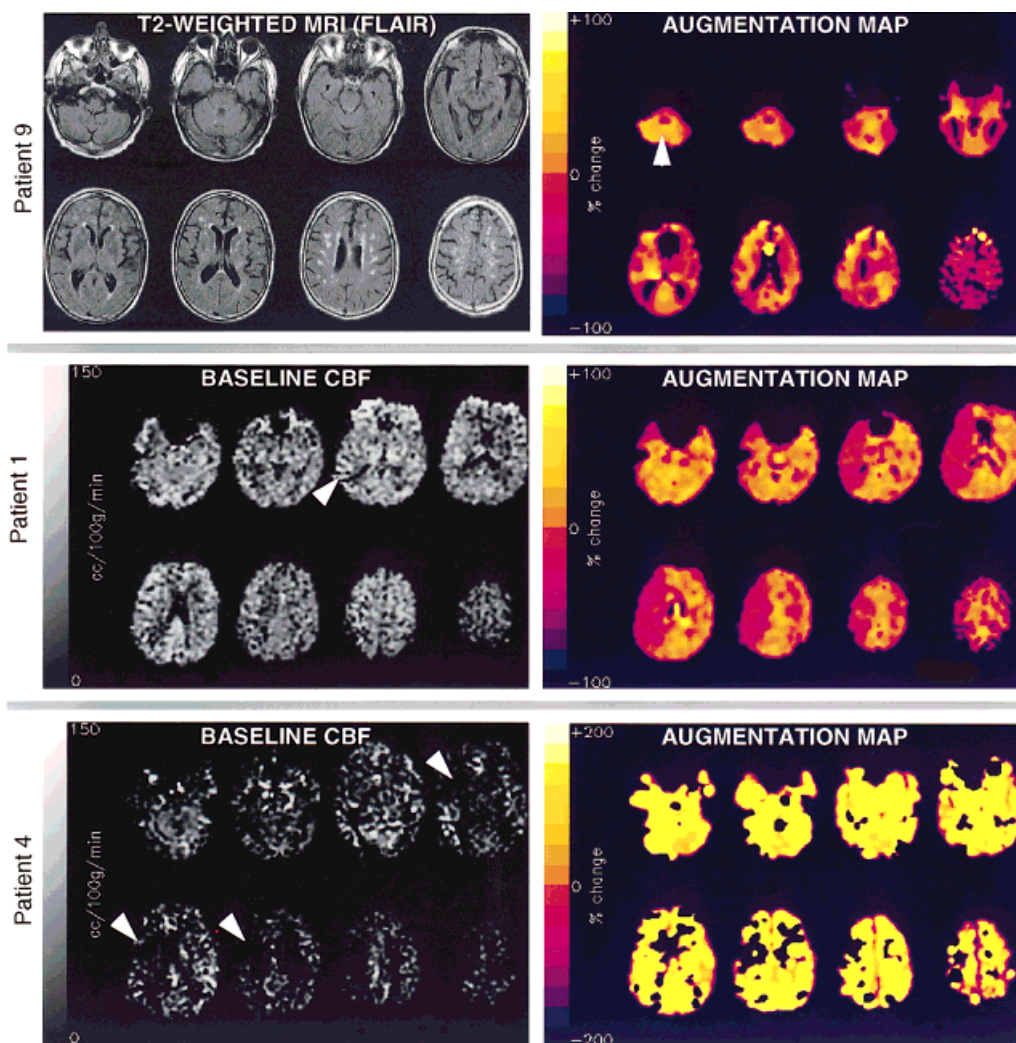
Examples of image data acquired using continuous arterial spin labeling (CASL) perfusion magnetic resonance imaging (MRI) with acetazolamide. Top: Data acquired from patient 9. On the left, T2-weighted, fluid-attenuated inversion recovery (FLAIR) images show subcortical ischemic changes in the anterior circulation distributions bilaterally. On the right, the augmentation map clearly shows minimal change in cerebral blood flow (CBF) in the anterior circulation, with the most pronounced augmentation in the posterior circulation distribution (arrowhead). The color scale shows the percent CBF change ranging from -100% to 100% of resting values. Middle: Data acquired from patient 1. On the left, the resting CBF appears grossly symmetrical, although linear hyperintensities suggesting delayed arterial transit are evident (arrowhead). The gray scale shows CBF values ranging from $0 \text{ ml} \cdot 100 \text{ g}^{-1} \cdot \text{min}^{-1}$ to $150 \text{ ml} \cdot 100 \text{ g}^{-1} \cdot \text{min}^{-1}$. On the right, the augmentation map demonstrates an augmentation deficit in the right middle cerebral artery (MCA) distribution. The color scale shows percent flow change ranging from -100% to 100% of resting values. Bottom: Data acquired from patient 4. On the left, the resting CBF is very low throughout, with a deficit in the right anterior MCA distribution corresponding to the location of an anterior MCA infarct (arrowheads). The gray scale shows CBF values ranging from $0 \text{ ml} \cdot 100 \text{ g}^{-1} \cdot \text{min}^{-1}$ to $150 \text{ ml} \cdot 100 \text{ g}^{-1} \cdot \text{min}^{-1}$. On the right, the augmentation map demonstrates a marked CBF increase, except in the region of prior infarction. The color scale shows percent flow change ranging from -200% to 200% of resting values.
